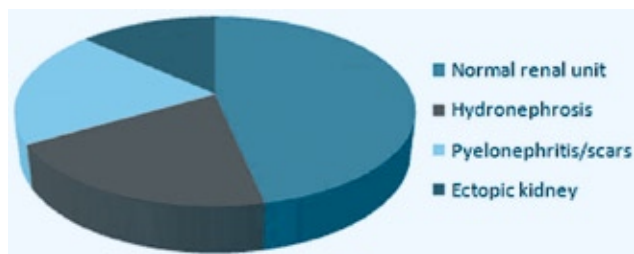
Pie chart showing scintigraphic findings in 15 patients with solitary functioning kidney. Seven of the 15 visualized renal units were normal. The remaining 8 had various abnormalities.
